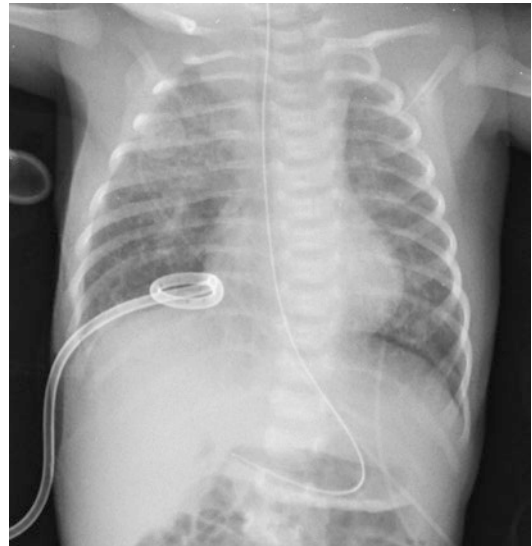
Chest X-ray after the placement of a thoracic drain on the right side, same neonate as Figs. 19.1 and 19.2
